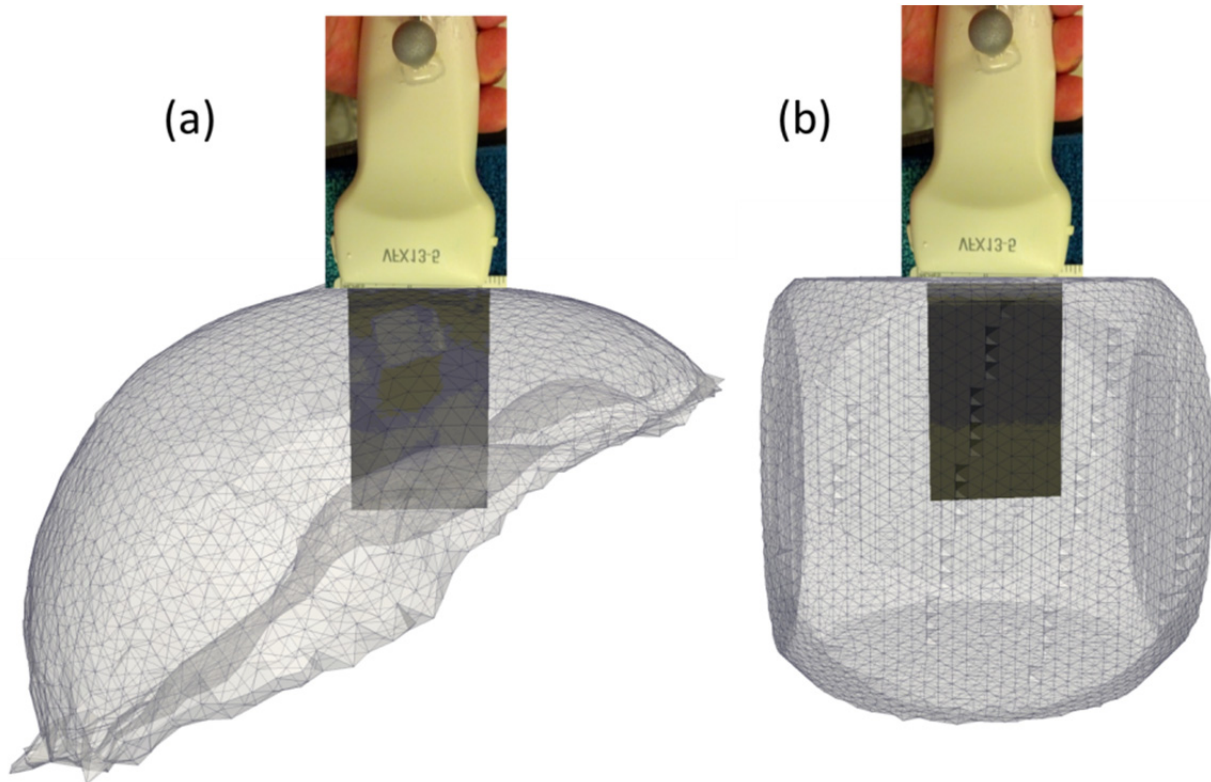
Example of a mesh used for the patient-specific model correction method (a), constructed from preoperative imaging and aligned to the ultrasound data using intraoperative registration methods, and an example of a block mesh for the generic model correction method (b), which is pre-aligned to the ultrasound data by performing a calibration to the ultrasound probe.
